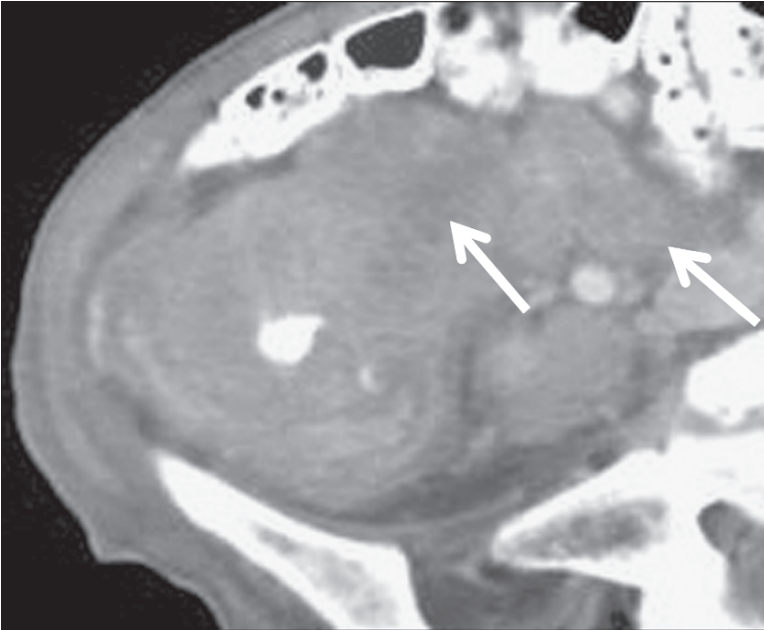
Axial contrast-enhanced CT scan demonstrates a bulky mass arising from the cecum, with enlarged lymph nodes in the regional mesentery (arrows)
